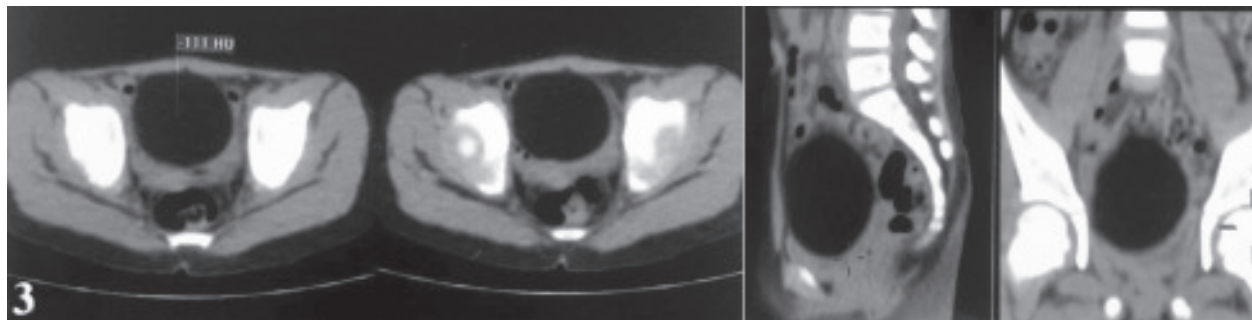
Selected images of non-contrast multi-plane CT scan of abdomen showing a well outlined oval intraperitoneal soft tissue mass (measuring $\sim 8.5 \times 6.5 \times 5$ cm) of fat-like radio-density in the pelvis, surrounded by loops of bowel, above urinary bladder, well away from any major organ or blood vessel, possibly originating from the mesentery.
